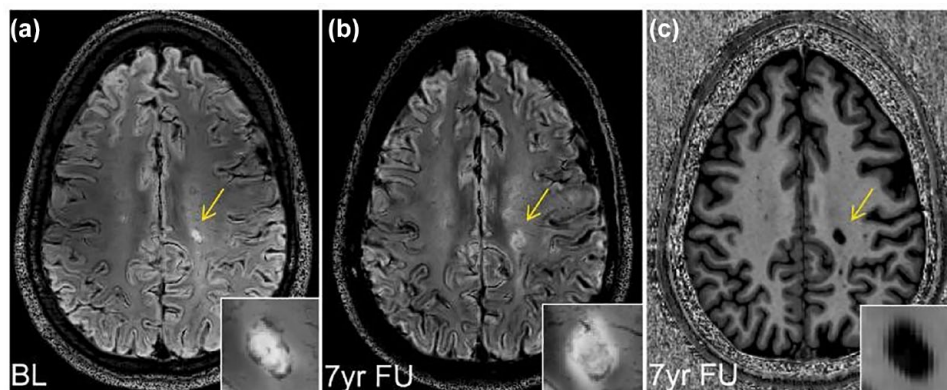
Longitudinal presentation of a PRL visualized using 7T FLAIR-SWI. 7T MRI scans are from a person with MS for 12 years and an MSSS of 3.94. The person is converted from RRMS to SPMS by the 7-year follow-up MRI. Panels a and b are 7T FLAIR-SWI and panel c is 7T MP2RAGE. The yellow arrows in panels a and b indicate the development of a PRL in the supratentorial white matter within 7 years enlarged in the respective bottom right corner. At baseline (a), the PRL presents as a hyperintense FLAIR lesion surrounded by an SWI-hypointense iron rim. At follow-up (b), the SWI-hypointense iron rim has diminished and is now surrounded by an evolved perilesional FLAIR hyperintensity, resulting from retrograde axonal damage (“Wallerian degeneration”). SWI-hypointense punctate or horizontal signals are also seen within this lesion, indicating veins and diffuse perivascular iron accumulation. Panel c shows marked MP2RAGE hypointensity of the PRL at 7-year follow-up, reflecting the pronounced tissue destruction of PRLs. 7T MRI scans were performed at the High-Field MR Center of the Department of Biomedical Imaging and Image-Guided Therapy, Medical University of Vienna. BL, baseline; FLAIR, fluid attenuated inversion recovery; FU, follow-up; MP2RAGE, magnetization-prepared two rapid acquisition gradient-echo; MS, multiple sclerosis; MSSS, MS Severity Score; PRL, paramagnetic rim lesion; RRMS, relapsing-remitting MS; SPMS, secondary progressive MS; SWI, susceptibility-weighted imaging; T, Tesla.
